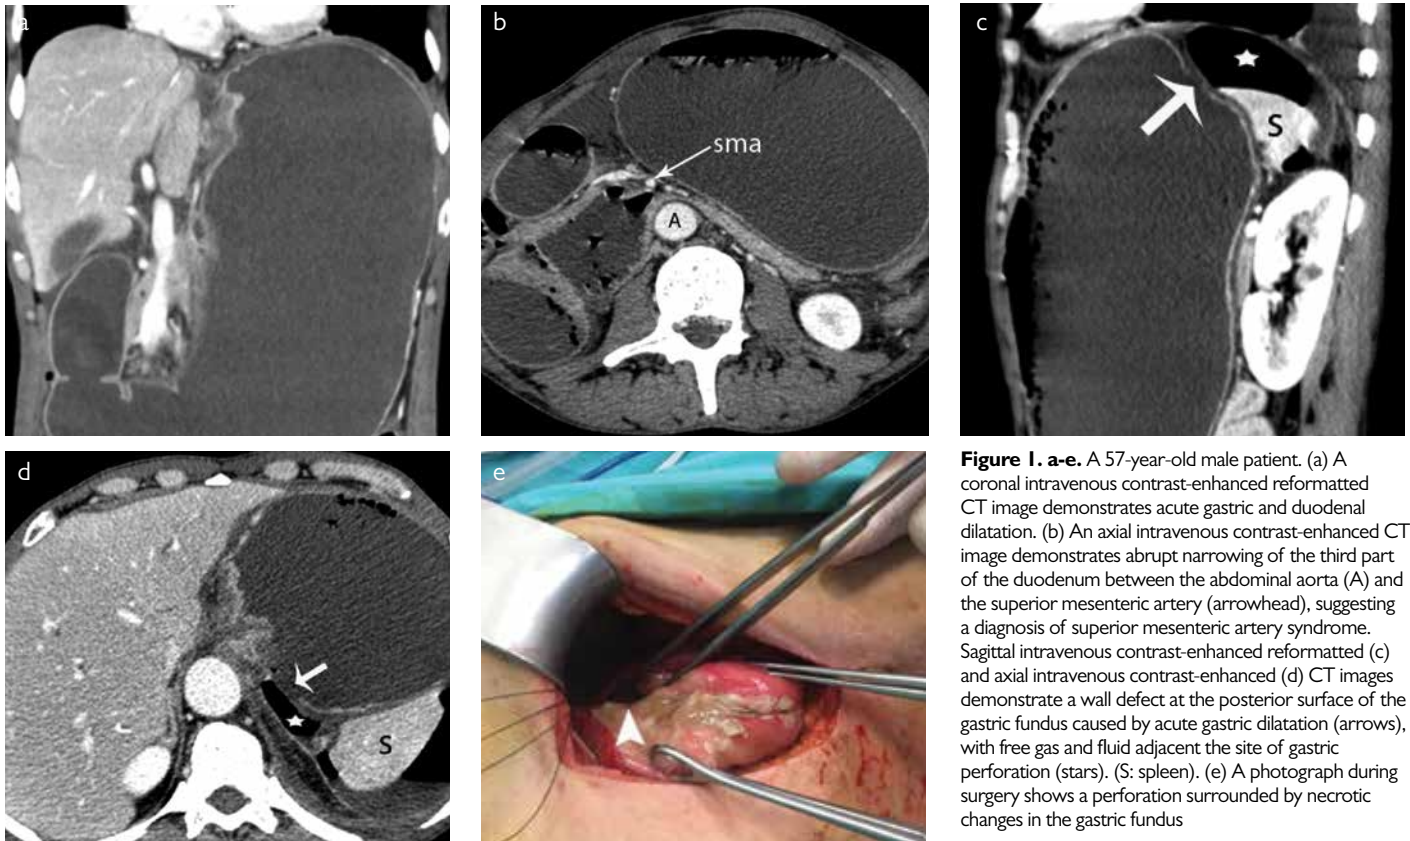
a-e. A 57-year-old male patient. (a) A coronal intravenous contrast-enhanced reformatted CT image demonstrates acute gastric and duodenal dilatation. (b) An axial intravenous contrast-enhanced CT image demonstrates abrupt narrowing of the third part of the duodenum between the abdominal aorta (A) and the superior mesenteric artery (arrowhead), suggesting a diagnosis of superior mesenteric artery syndrome. Sagittal intravenous contrast-enhanced (c) and axial intravenous contrast-enhanced (d) CT images demonstrate a wall defect at the posterior surface of the gastric fundus caused by acute gastric dilatation (arrows), with free gas and fluid adjacent the site of gastric perforation (stars). (S: spleen). (e) A photograph during surgery shows a perforation surrounded by necrotic changes in the gastric fundus
